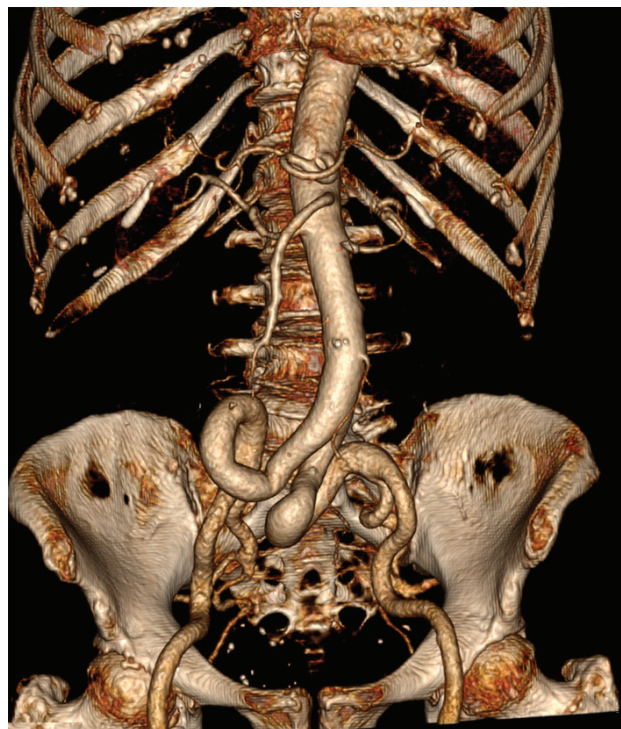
CTA presenting coiling of dilated right CIA and coiling of dilated left CIA, together with elongated left EIA
